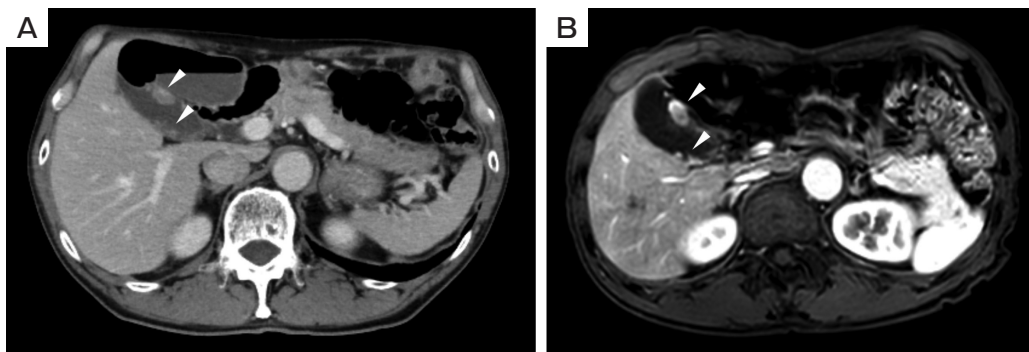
A, Contrast-enhanced CT scan showed multiple nodules with contrast effects up to 15 mm in size in the gallbladder (white arrowheads); B, Contrast-enhanced MRI showed multiple nodules in the gallbladder similar to CT, with contrast effect and diffusion limitation (white arrowheads).
